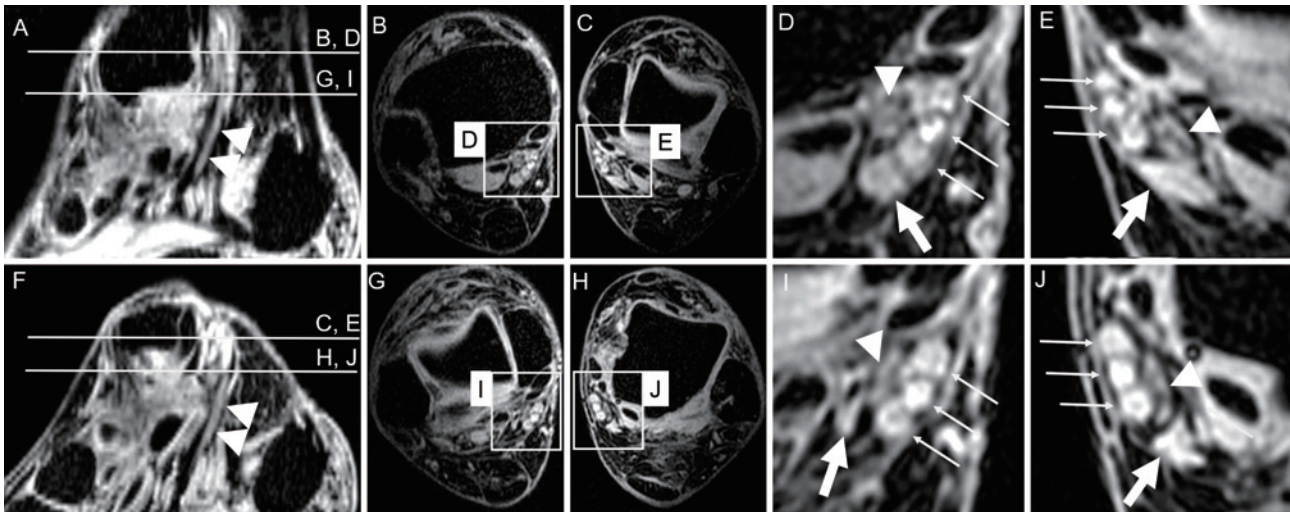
MRI scans of the tarsal tunnel (fat suppression T2*).
